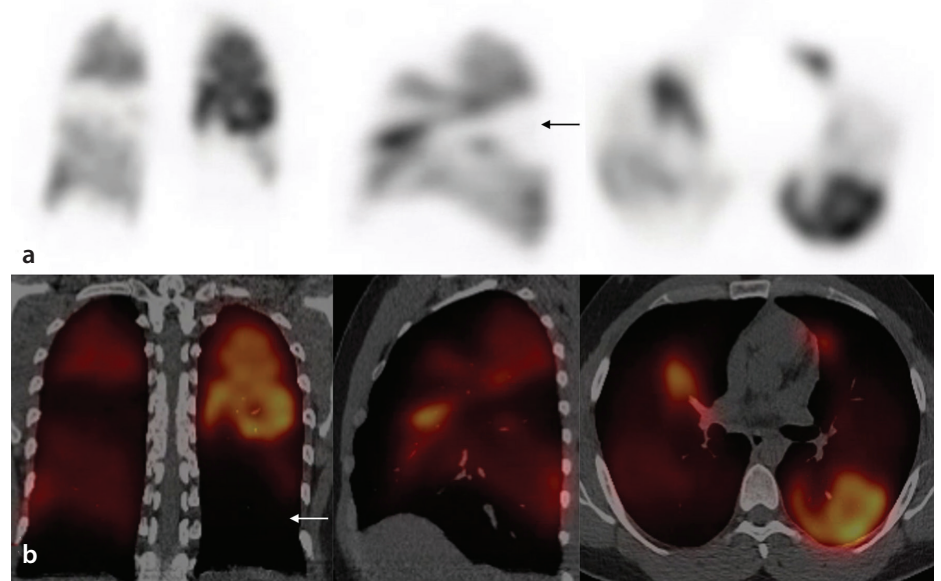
Selected images of coronal, sagittal, and axial single-photon emission computed tomography (SPECT) perfusion (a, top panel) and corresponding fusion images of SPECT perfusion and CT (b, bottom panel). Multiple bilateral lobar perfusion defects (white arrow) and segmental (black arrow) distribution in a 45-year-old man with chronic thromboembolic pulmonary hypertension.
